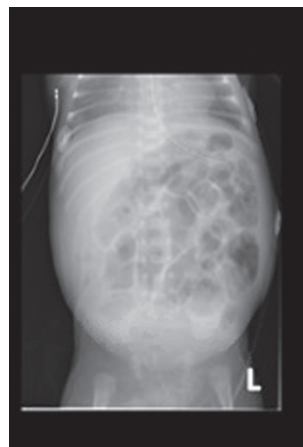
Case 1. Abdominal x-ray one day after application of support.
